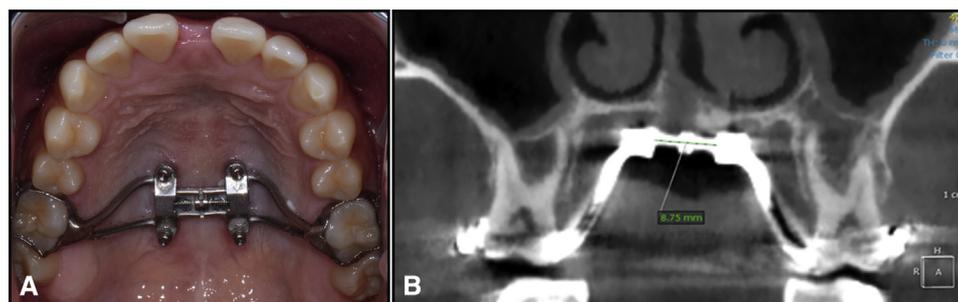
Maxillary skeletal expander: A, intraoral occlusal view; B, CBCT section showing the distance between the 2 halves of the expansion jackscrew after expansion on a patient. The opening of the midpalatal suture can also be appreciated. Reprinted with permission from Cantarella D et al. Changes in the midpalatal and pterygopalatine sutures induced by micro-implant-supported skeletal expander, analyzed with a novel 3D method based on CBCT imaging. *Prog Orthod* 2017;18:34, Elsevier.
